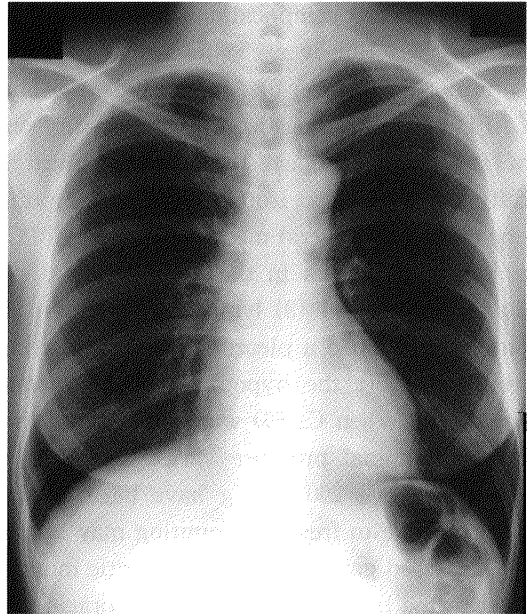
Chest radiograph after extracorporeal ultrafiltration showing the absence of right pleural effusion.
